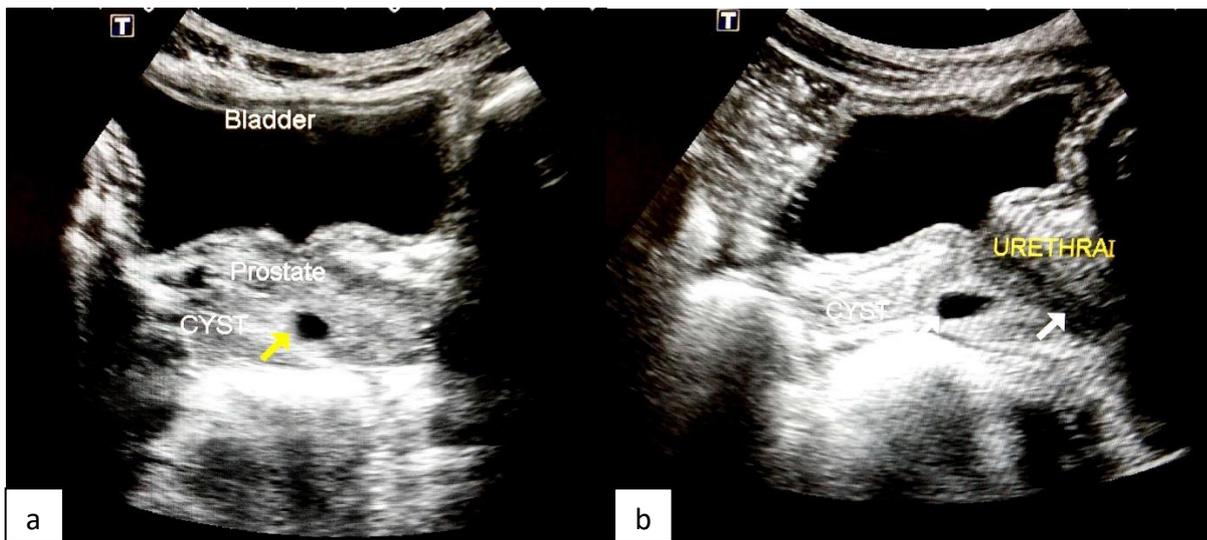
Transabdominal ultrasound showing in transverse (a) and longitudinal (b) views, anterior midline prostatic cyst.
